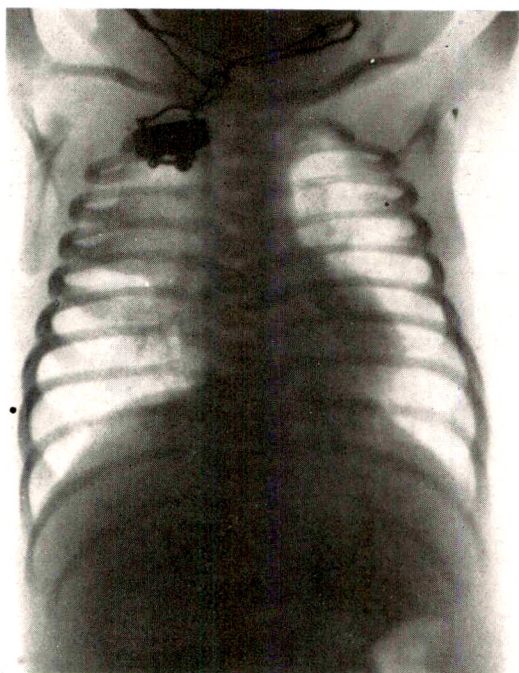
Congenital atelectasis. Baby S., one day old; patient of Drs. Thaddeus L. Montgomery and Edward F. Burt; cyanosis, wheeze; upper portion of right chest evenly dense due to failure of upper lobe to expand. Ribs unelevated over this portion of chest. Roentgenograms made ten days later showed a normal chest.
